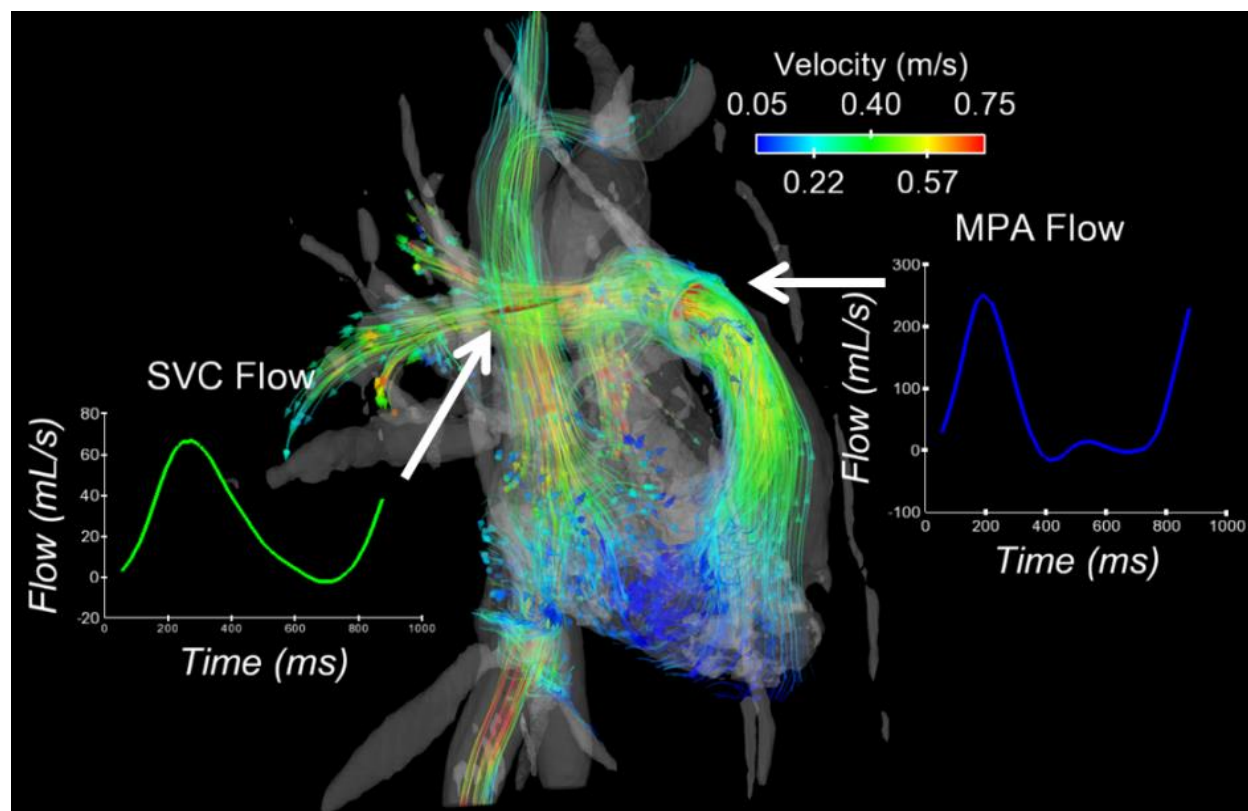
Example post-processed 4D flow MRI exam in the cardiac vessels. Velocity streamlines in right-side vessels at specific time-points provide qualitative visual assessment of flow patterns. Two-dimensional cutplanes (white arrows) can be interactively placed in vessels of interest (shown here in the superior vena cava – SVC and the main pulmonary artery – MPA). Integration of velocity values gives characteristic flow curves over the cardiac cycle.
